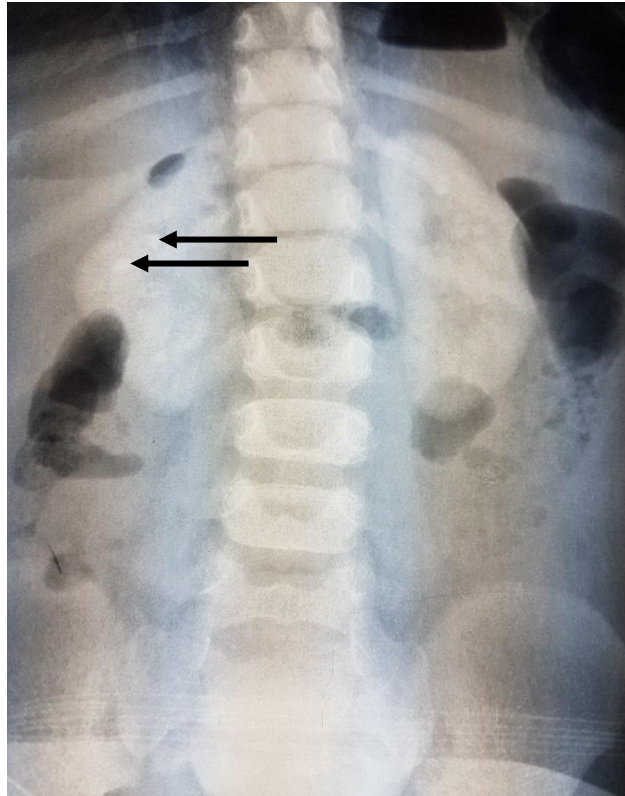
Abdominal x-ray of a patient with primary hyperoxaluria showing nephrocalcinosis, as delineated by the radio-opacities outlining both kidneys, and urolithiasis as indicated by the arrows.
